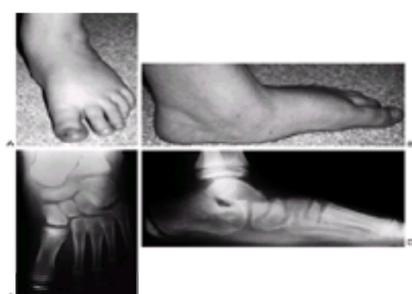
Adolescent skewfoot, i.e., valgus deformity of the hindfoot with adductus of the forefoot. A and B: Photographs. C and D: Radiographs.
